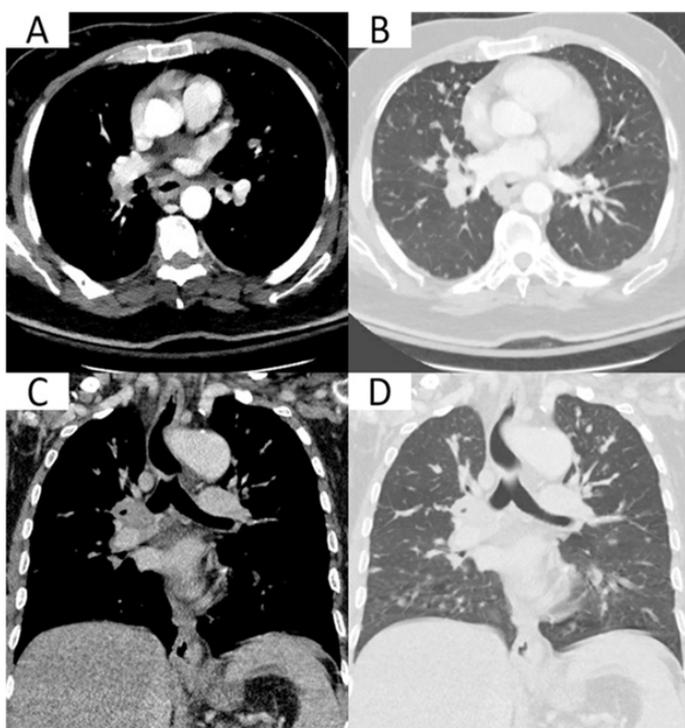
Pre-treatment chest computed tomography in axial (A,B) and coronal (C,D) views show a right hilar mass with associated lymphadenopathy. Lung windows (B,D) reveal multiple bilateral pulmonary nodules.
